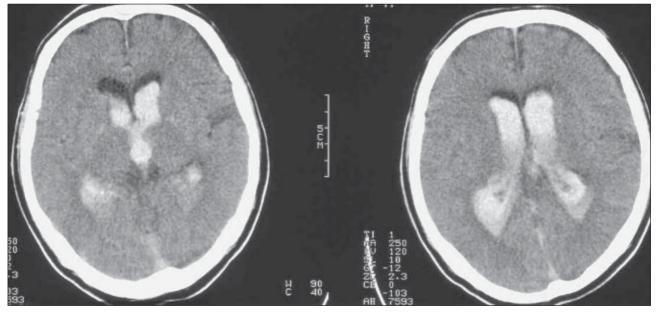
Computed tomography scans showing massive intraventricular haemorrhage at the third and fourth ventricles
